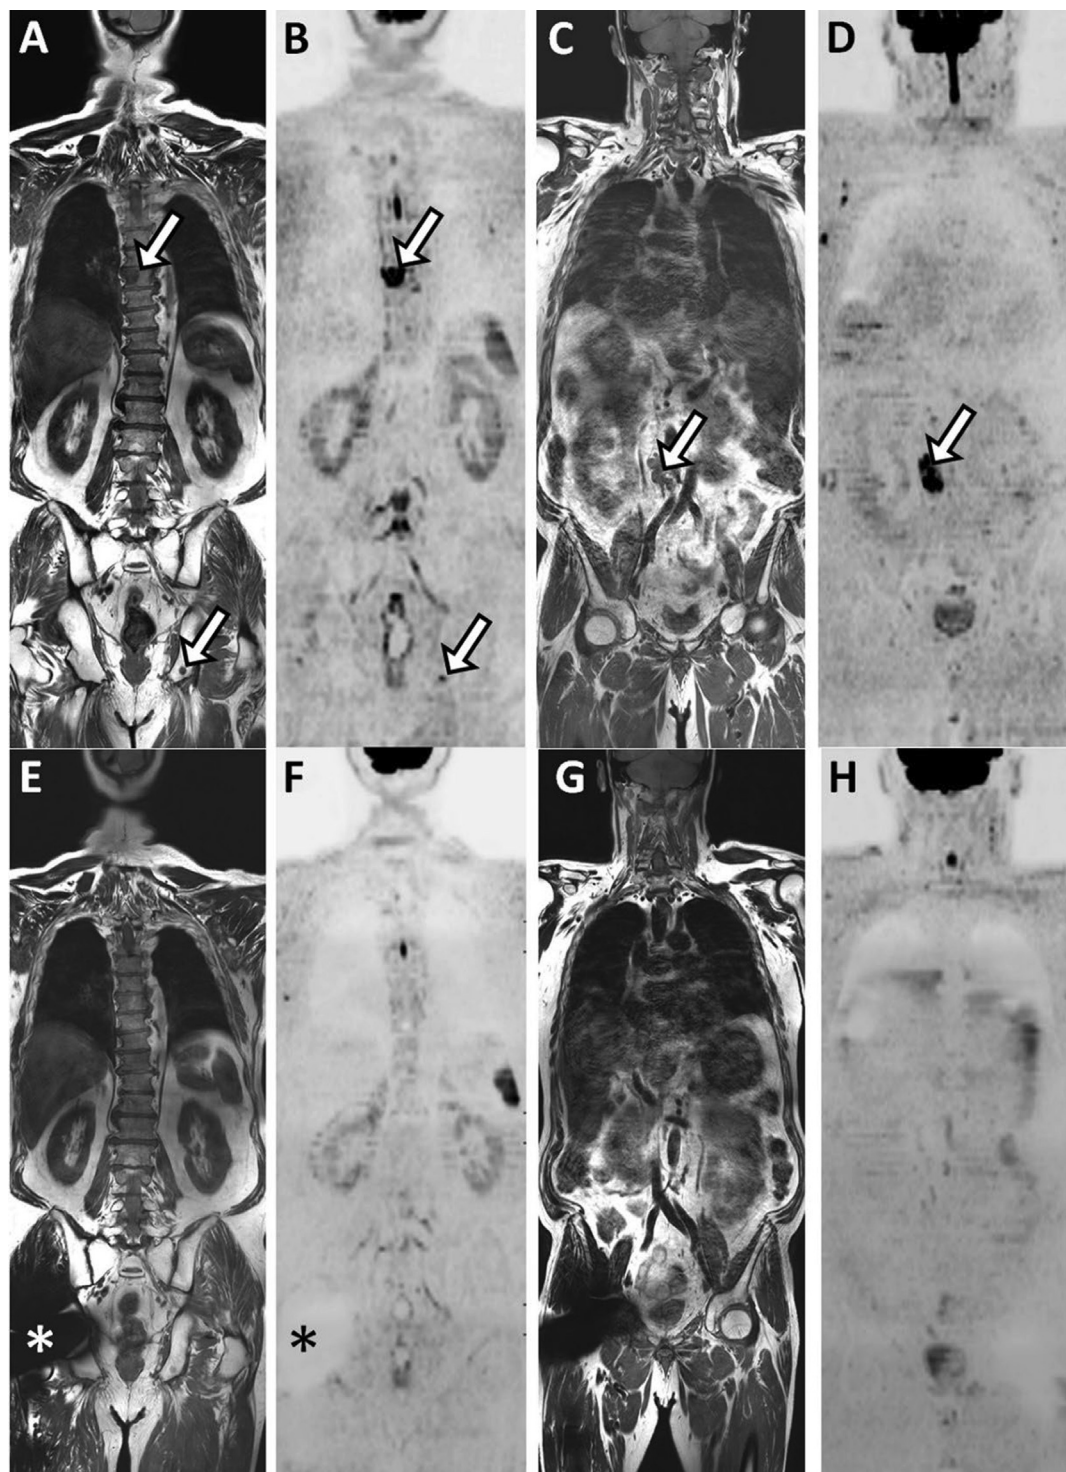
Response of bone and node metastases in a 73-yr-old man with metastatic hormone-naïve prostate cancer (response assessment category 1). Comparison of whole-body magnetic resonance imaging before and after treatment. (A,C) Coronal T1-weighted images and (B,D) DWI scans ($b = 1000 \text{ s/mm}^2$, inverted gray scale) at baseline show typical bone metastases within the T7 vertebral body and left ischiatic tuberosity (arrows in A and B) and lumbo-aortic node metastases (arrows in C and D). (E–H) Corresponding 6-mo follow-up images show complete disappearance of all metastatic foci (subtle residual marrow signals on T1-weighted images correspond to scar tissue). Right total-hip arthroplasty was performed between the time points, explaining the artifacts denoted by asterisks in E and F. DWI = diffusion-weighted imaging.
